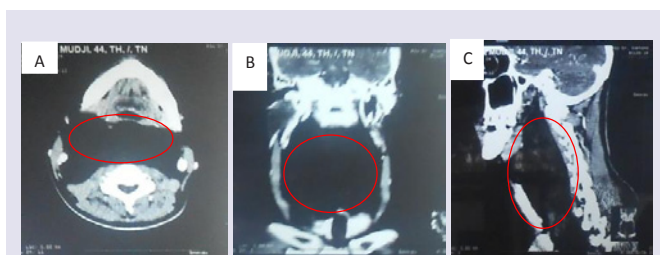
Head and neck CT scan revealed fat dominant lesion in retropharyngeal space as high as corpus VC 2-6 with a size of 10 x 5 x 10 cm.
